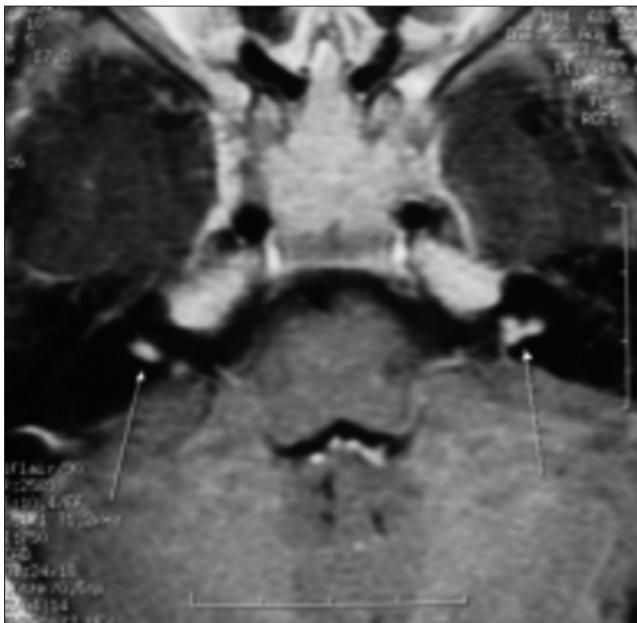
Axial T1-weighted magnetic resonance image of the brain in a child with a congenital form of NF2 obtained at age 4 months showing bilateral vestibular schwannomas (case 1, ref. 34).
